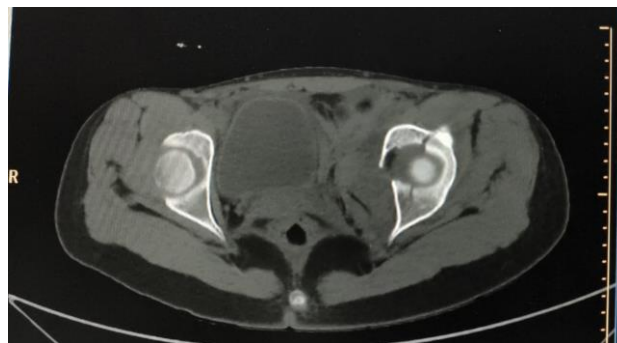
CT Scan of the pelvis in the horizontal view A complete fracture is observed in the anterior column and an incomplete fracture in the posterior column
